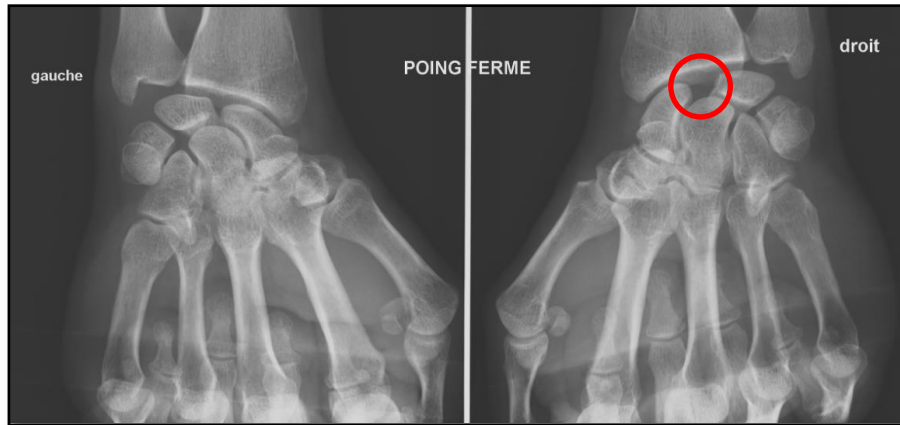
Exemple radiographique d'une ISL dynamique avec apparition d'un diastasis scapho-lunaire sur le cliché de face poing serré, poignet droit.
